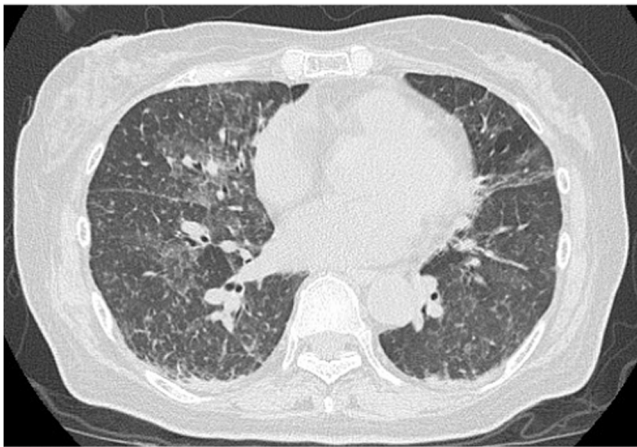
Chest computed tomography (CT). Chest CT shows bilateral ground-glass opacity, interlobular septal thickening, and multiple random granular shadows.
